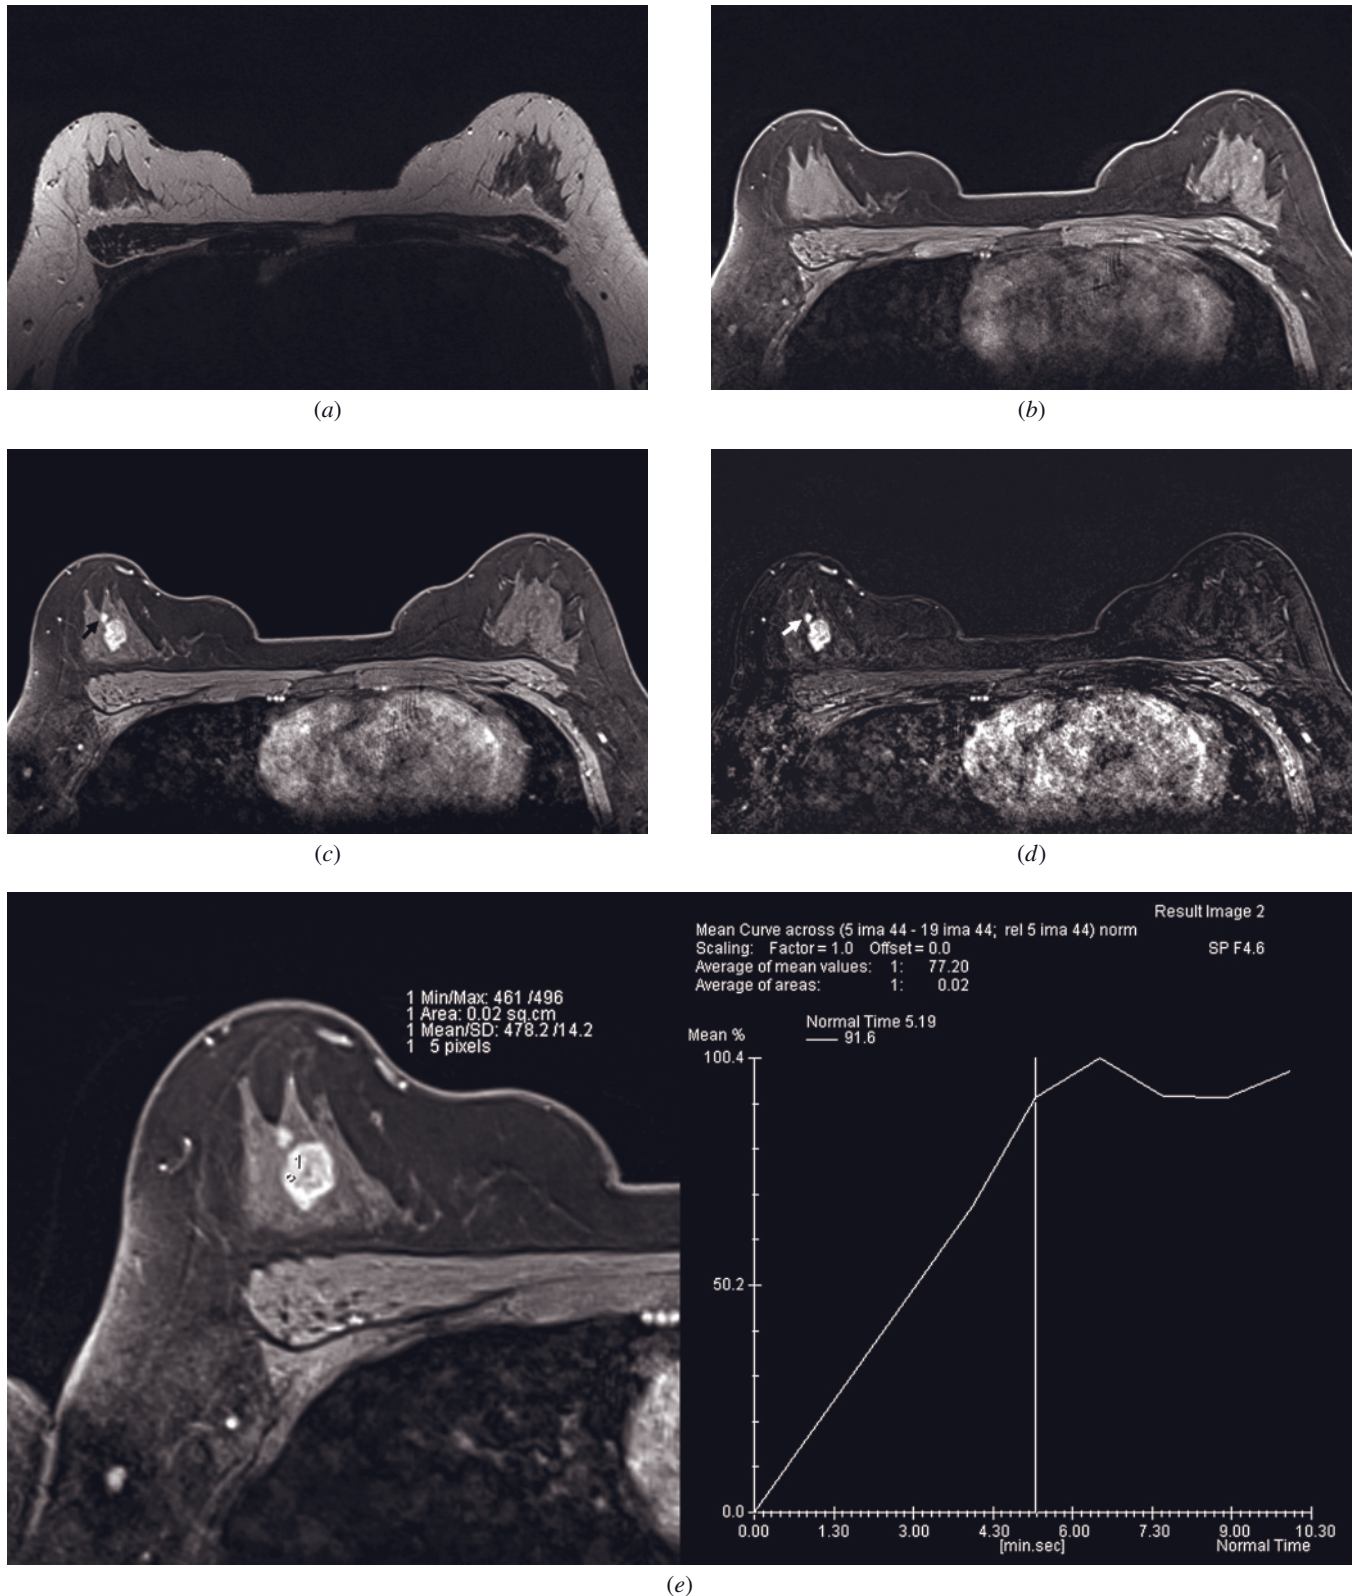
Invasive ductal carcinoma (IDC). Axial T2-weighted image (a) shows a very subtle, slightly hyperintense oval mass with irregular margins in the right breast. On the axial precontrast GRE image (b), the mass is completely obscured, because it is of the same signal intensity as the surrounding parenchyma. Postcontrast GRE (c) and subtracted (d) images reveal a strongly enhancing mass with angulated, irregular margins and heterogeneous internal enhancement, suggestive of IDC. ROI analysis of the dynamic data set (e) shows a plateau curve (Type II), indicating BI-RADS 5 categorization. Small enhancing mass (arrows, c and d) anterior to the IDC represents a focus of high-grade DCIS with the same type of kinetics (f).
